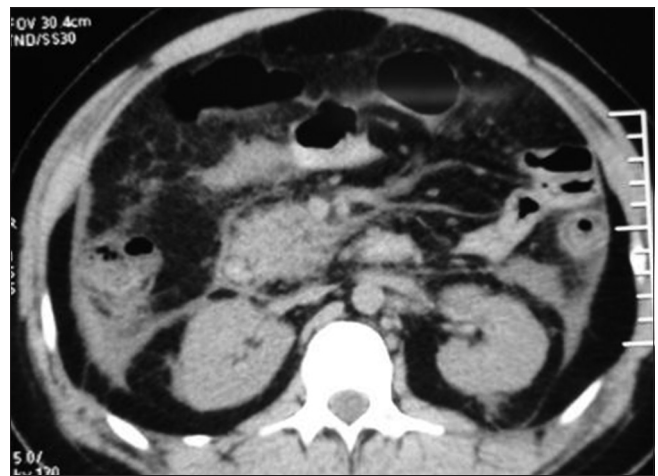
Computed tomography scan abdomen showing oedematous pancreatitis on day 13 of pancreatitis
